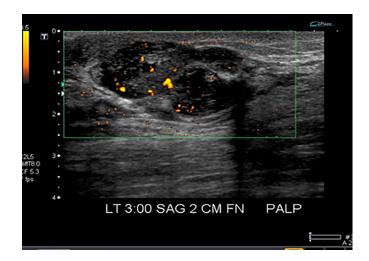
(Patient no. 2): Ultrasound of left breast at 3 o'clock location shows a solid, heterogeneously hypoechoic, well circumscribed, gently lobulated mass in parallel orientation which has angular margins, with posterior acoustic shadowing and has low flow internal and peripheral vascularity on color Doppler.
